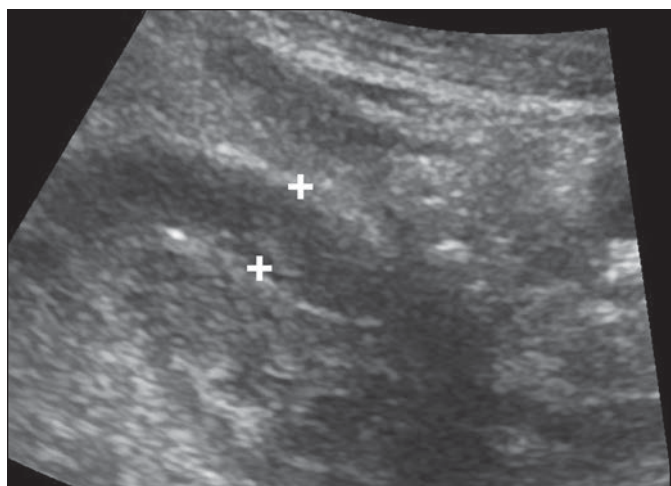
38-year-old woman with appendicitis who was not included in sample of 197 patients. Sonographic images show value of sonography performed with 6-MHz transducer after nonvisualization of appendix on sonography performed with 10-MHz transducer.
